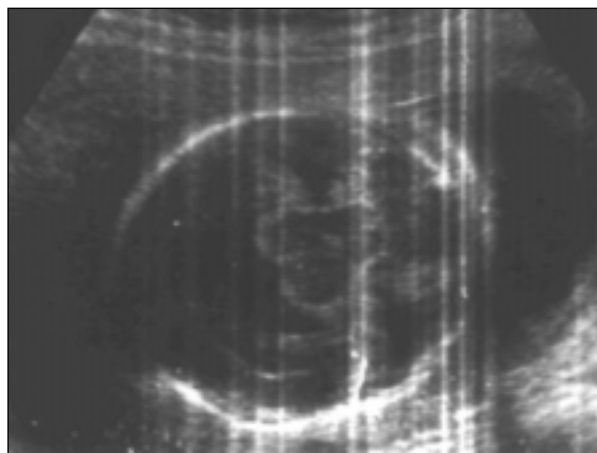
Ultrasonographic appearance of holoprosencephaly.
